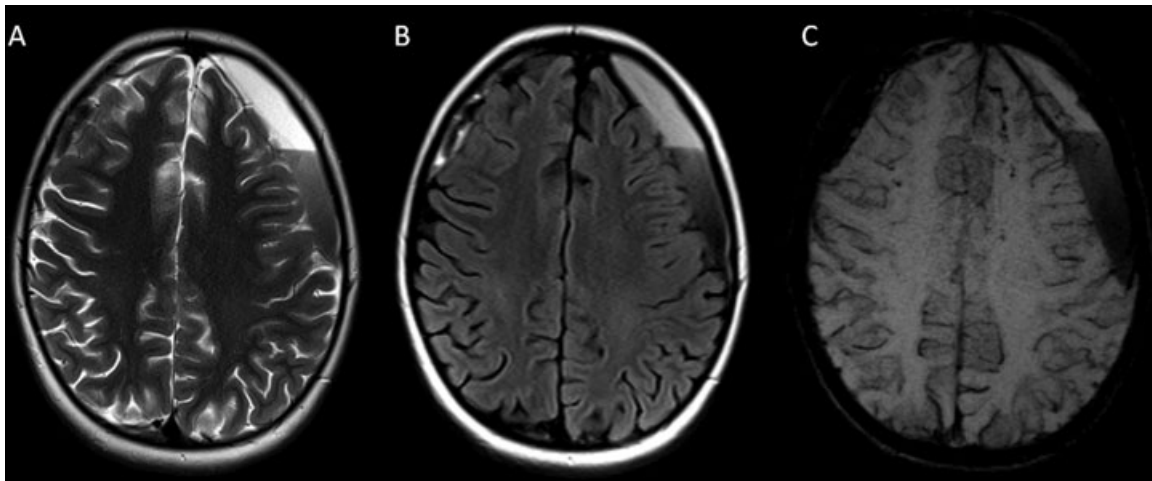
Axial T2-weighted (A), FLAIR (B), and SWI (C) MR images show a typical multilayered chronic, crescent shape subdural hematoma over the left frontal region. This SDH extends over the coronal suture. SWI images show prominent, engorged superficial veins along the left frontal lobe.
